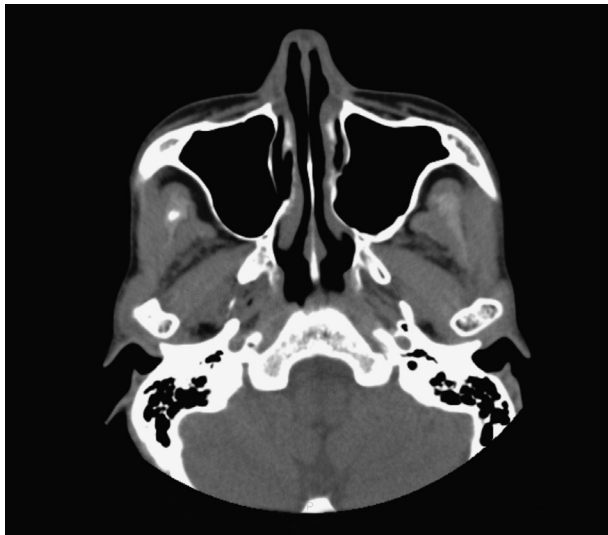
Postoperative CT of case 2. The sinus is completely clear 16 months after surgery.
